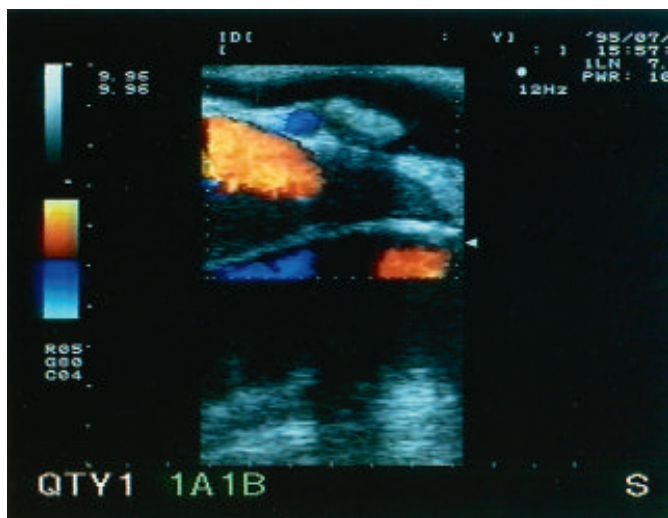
Proximal common bile duct, dilated 11 mm in diameter with a large stone; an acoustic shadow can be seen behind the stone. In the upper left corner of the right hepatic artery (transverse section), are the portal vein and the vena cava in the far field of the vessels, demonstrated clearly by color Doppler.
